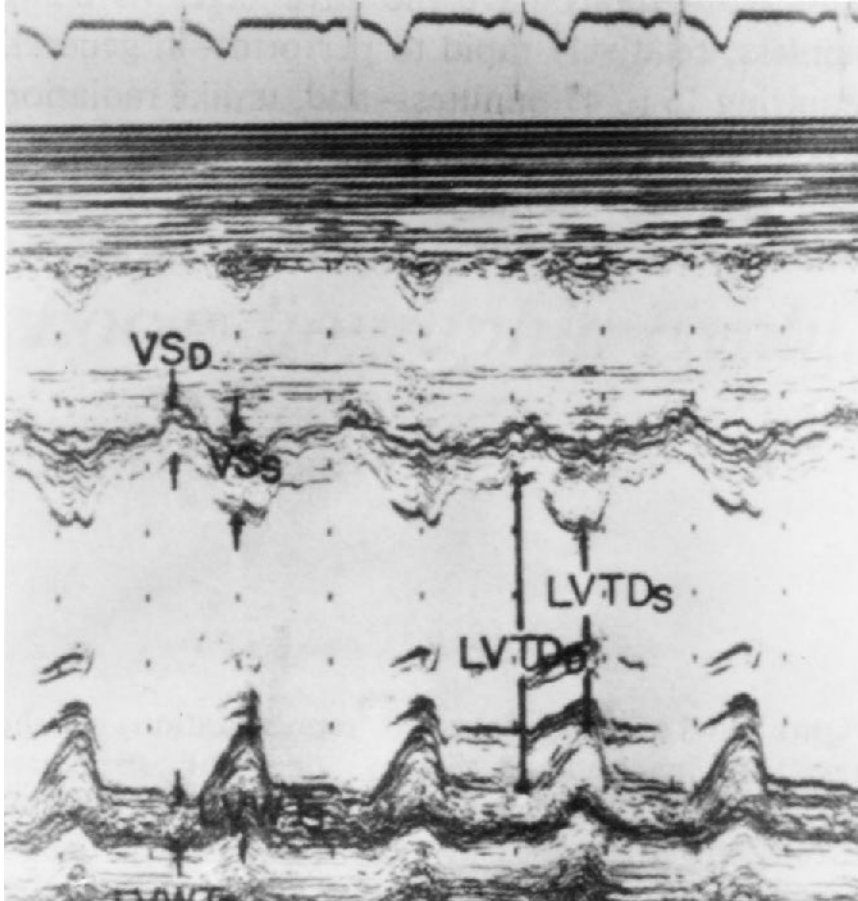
Echocardiographic recording of the left ventricle indicating measurements of parameters of left ventricular muscle mass and percentage fractional shortening. VS_D = interventricular septal thickness measured during diastole, VS_S = ventricular septal thickness measured during systole, $LVWT_D$ = left ventricle posterior wall thickness measured during diastole, $LVWT_S$ = left ventricular posterior wall thickness measured during systole, $LVID_D$ = left ventricular transverse dimension measured during diastole, $LVID_S$ = left ventricular transverse dimension measured during systole. (Reprinted from Drayer J, Gardin JM, Weber MA, Aronow WS. Changes in cardiac anatomy and function during therapy with alpha-methyl dopa: An echocardiographic study. *Curr Ther Res* 1982; 32:856–865, with permission.)
